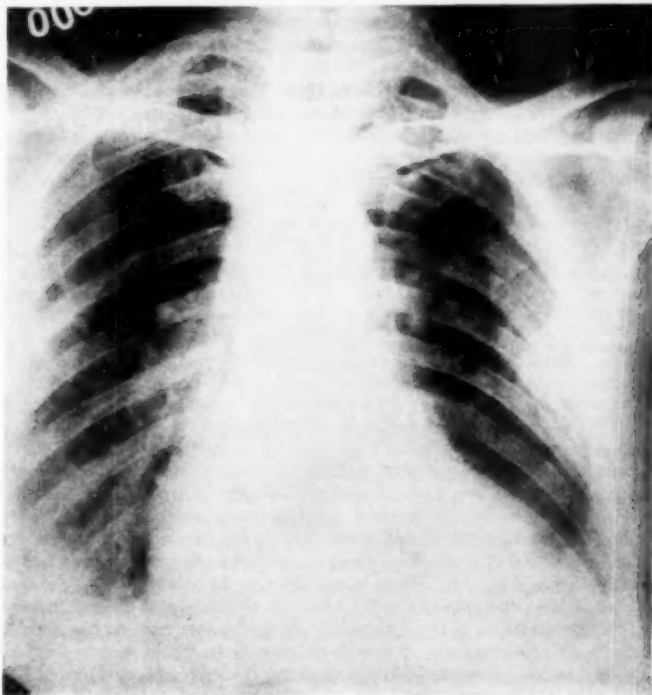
A roentgen-ray of the patient's chest taken shortly before institution of anticoagulant therapy. Opacities in right lower lobe and in left lung were thought to be consistent with the clinical picture of pulmonary infarction.
